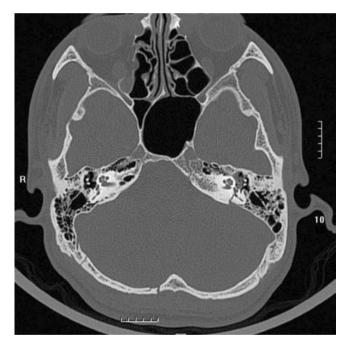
The left temporal bone transverse fracture CT scan
